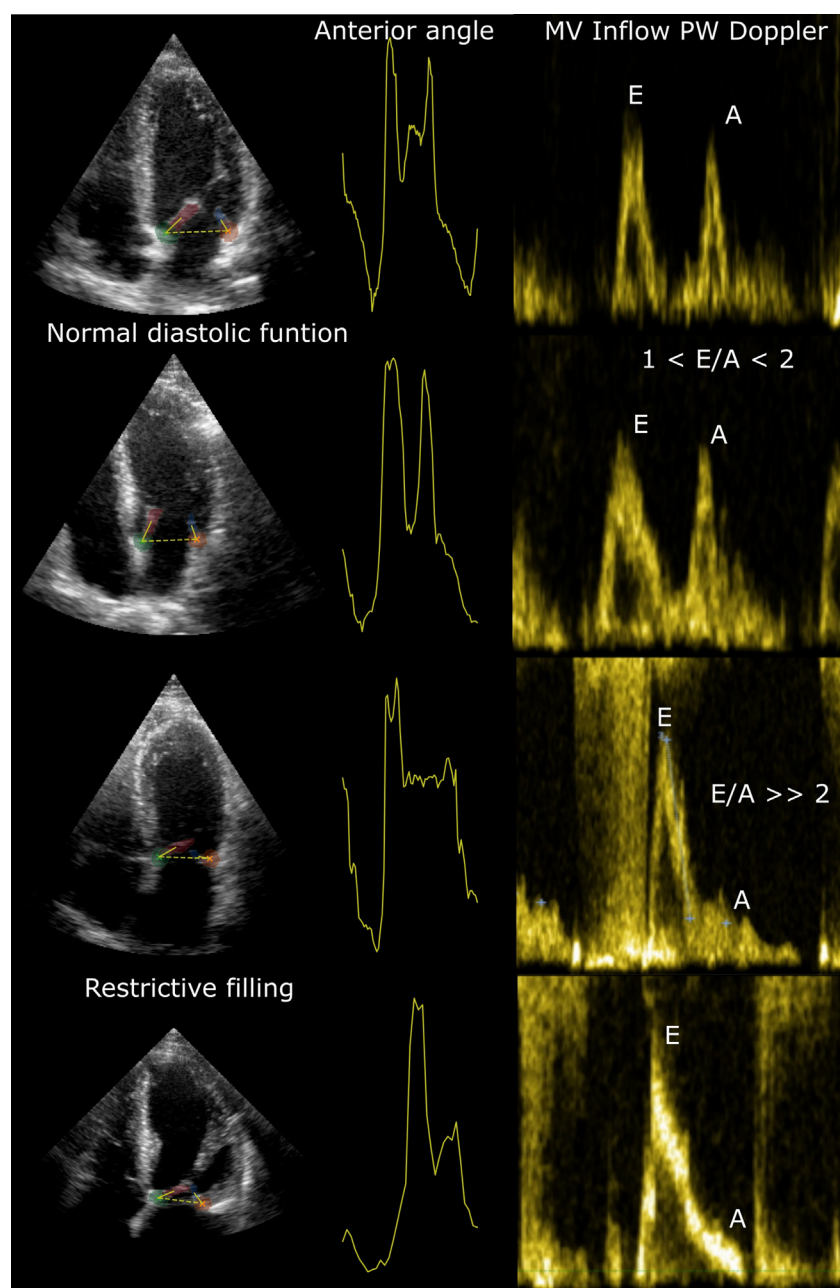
Tracking patterns of the anterior leaflet for A4C views in two cases of normal diastolic function (top) and two cases of restrictive filling (bottom). The tracking results (middle) are compared with MV Inflow Doppler spectra (right). We can observe that in cases of restrictive filling, the atrial systole peak angle is notably reduced, similar to the A wave velocity peak in the Doppler spectrum. MV, mitral valve; PW, pulsed wave.
